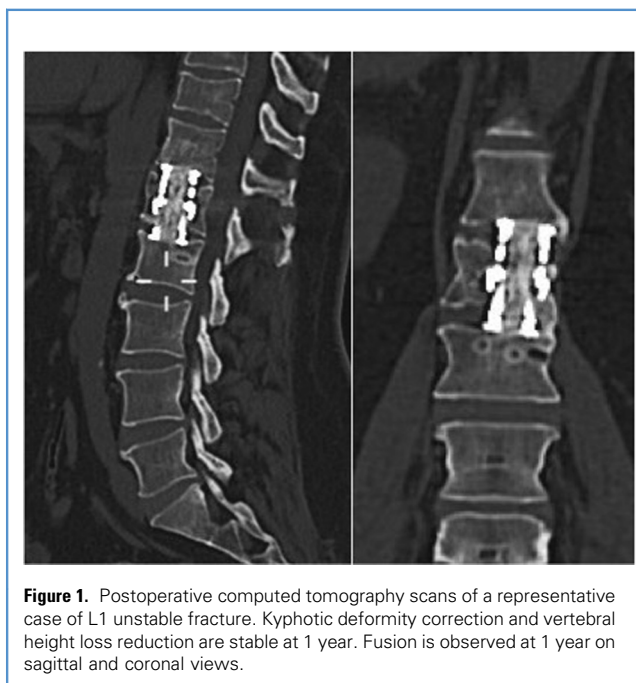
Postoperative computed tomography scans of a representative case of L1 unstable fracture. Kyphotic deformity correction and vertebral height loss reduction are stable at 1 year. Fusion is observed at 1 year on sagittal and coronal views.
